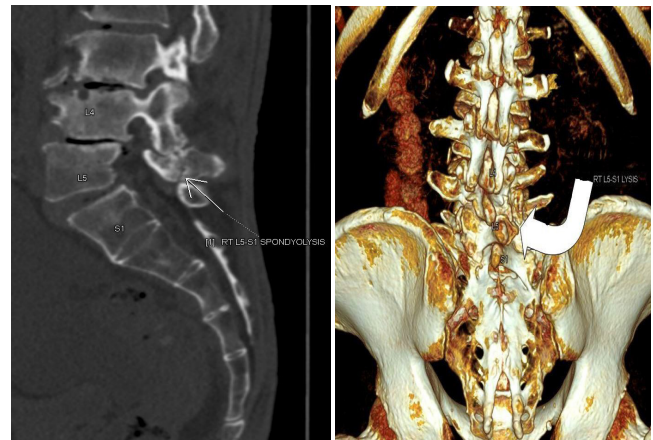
a) Sagittal CT MPR image of L5-S1 spondylolysis (arrow) b) Posterior view of 3D CT image of right sided L5-S1 spondylolysis (curved white arrow)
